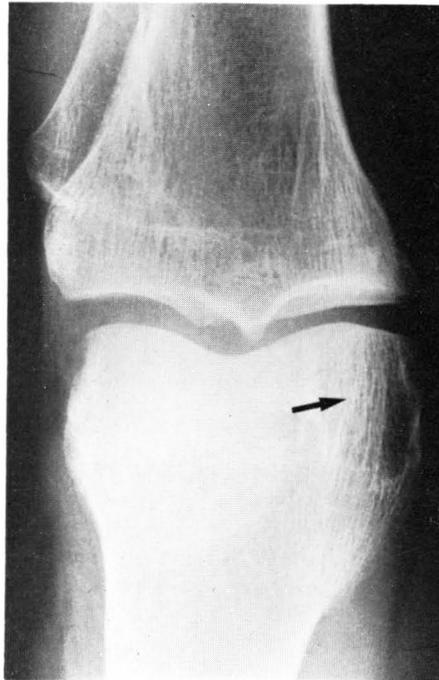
Plain film of the left femur. Note cystic changes of the bone (arrow).
